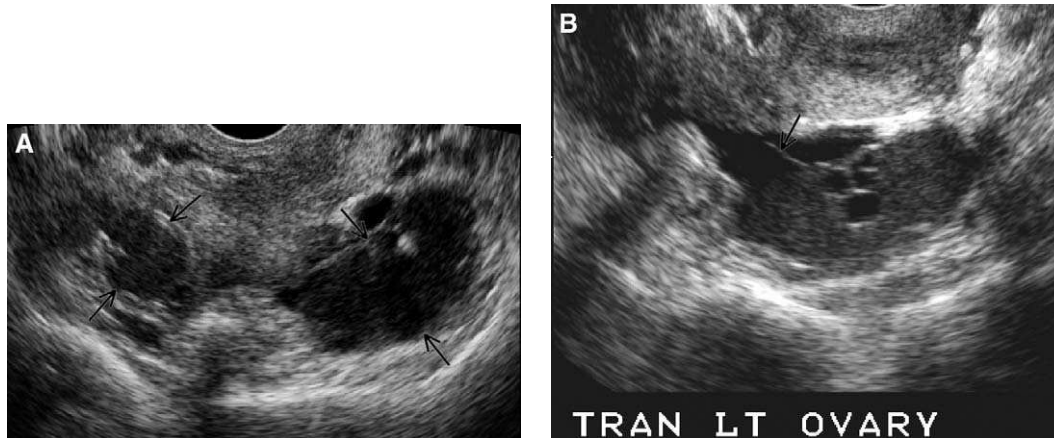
A 32-year-old woman with pelvic pain and infertility. (A) Transvaginal sonography demonstrates bilateral endometriomas (arrows) that are composed of low-level echoes. (B) On the left side, an adhesion from the ovary to the posterior cervix is demonstrated (arrow).
